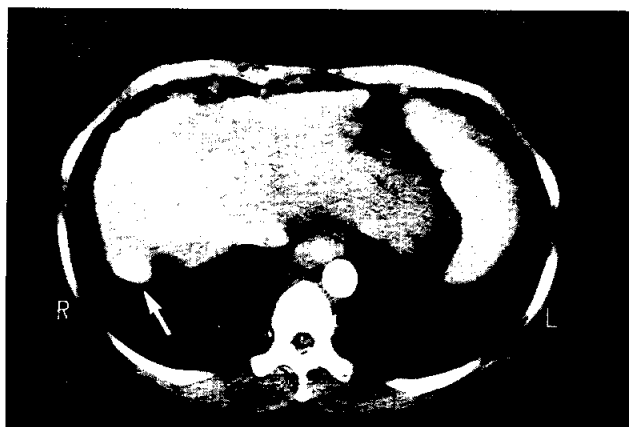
Post-lipoidal computed tomography scan of liver shows a nodule measuring 3 x 2 cm with intense enhancement at Segment VII (arrow)
